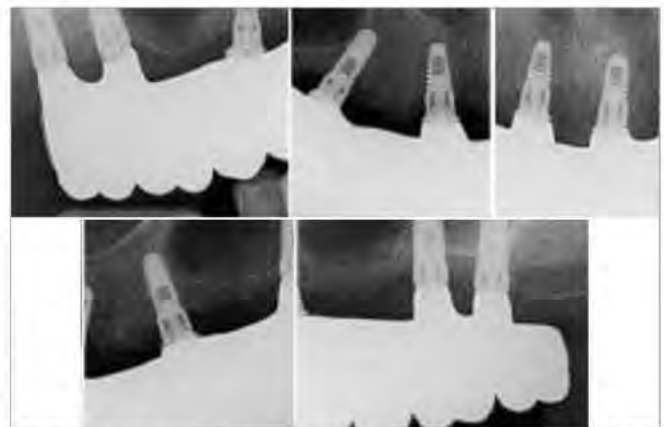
Periapical radiographs were taken to verify complete mating of the prosthetics with the implants without any misfit at the connectors.
